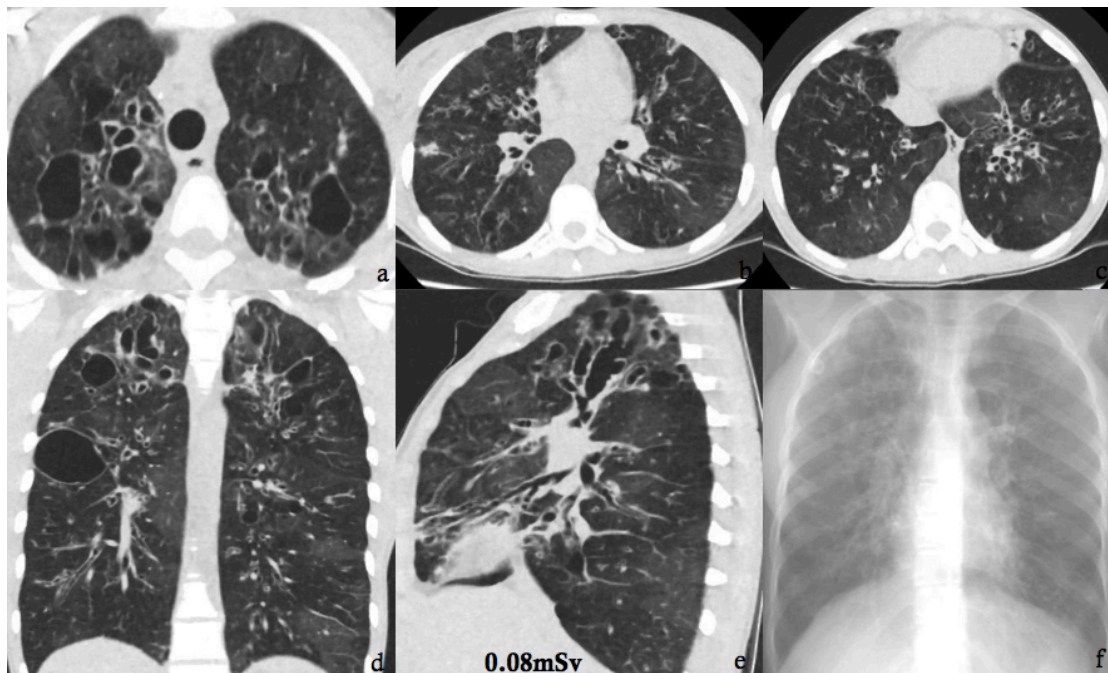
Representative multiplanar CT images (a-e) with a digital ray sum radiograph (f) acquired in 26-year-old male patient with cystic fibrosis at 24 months of treatment with Ivacaftor using the volumetric low-dose MBIR protocol (effective dose 0.08mSv). There is moderate bronchiectasis affecting between six
